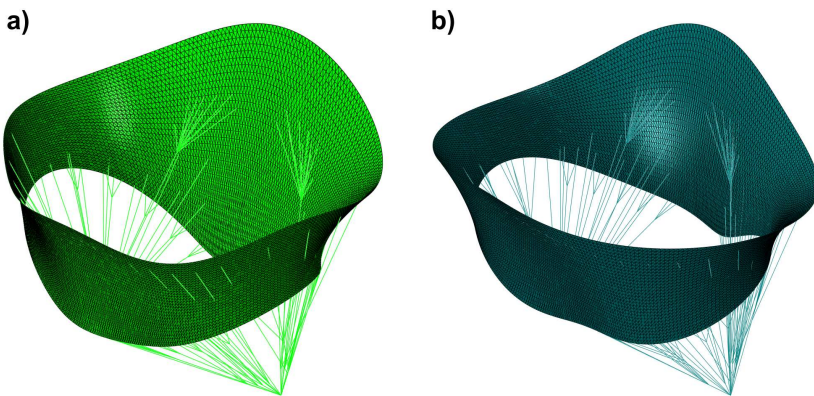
Computational models created using patient-specific echocardiographic image data: a) healthy mitral valve model; b) pathological model
